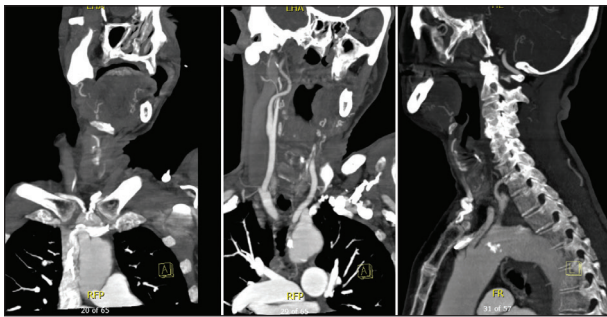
CTA coronal and sagittal MIPs showing a type III aortic arch.
